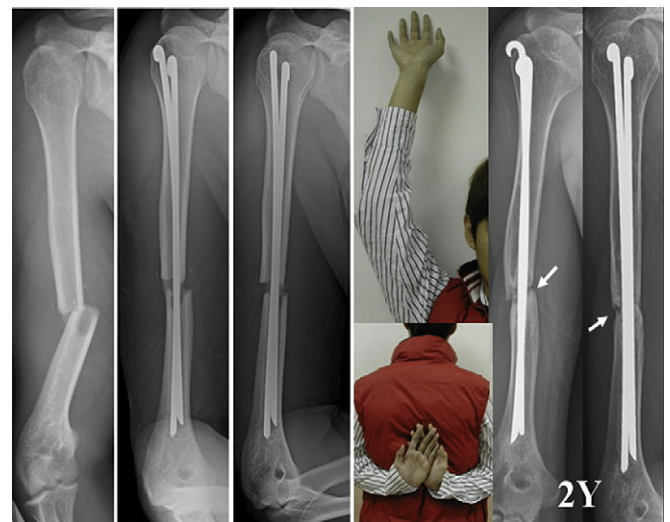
Radiographs of a 19-year-old, 171-cm-tall man who sustained an isolated AO type A3 humeral shaft fracture secondary to a scooter accident. Operation was done by closed reduction and intramedullary fixation using 24-cm and 26-cm Rush pins. Nonunion was noted 2 years after operation; the patient refused to receive autogenous bone grafting because of normal function of upper arm. Overdistraction of fracture is the reason for nonunion.
